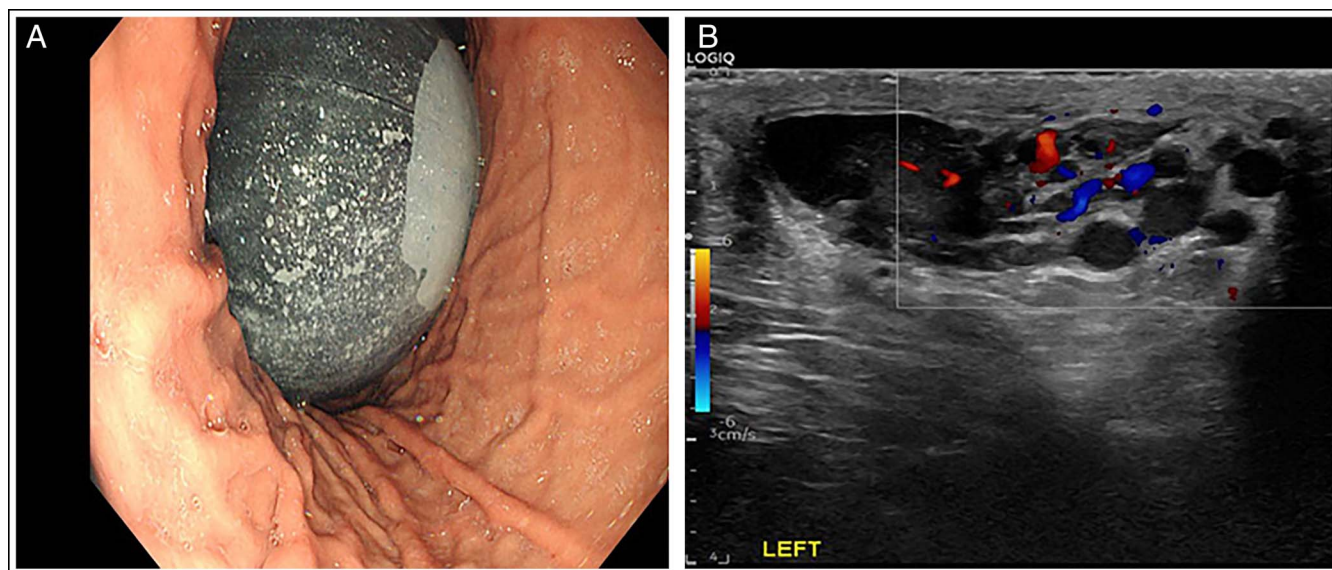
(A) Endogastric image showing the placement of the balloon in the gastric body. (B) Scrotal ultrasound of the left pampiniform plexus showing varicocele.
